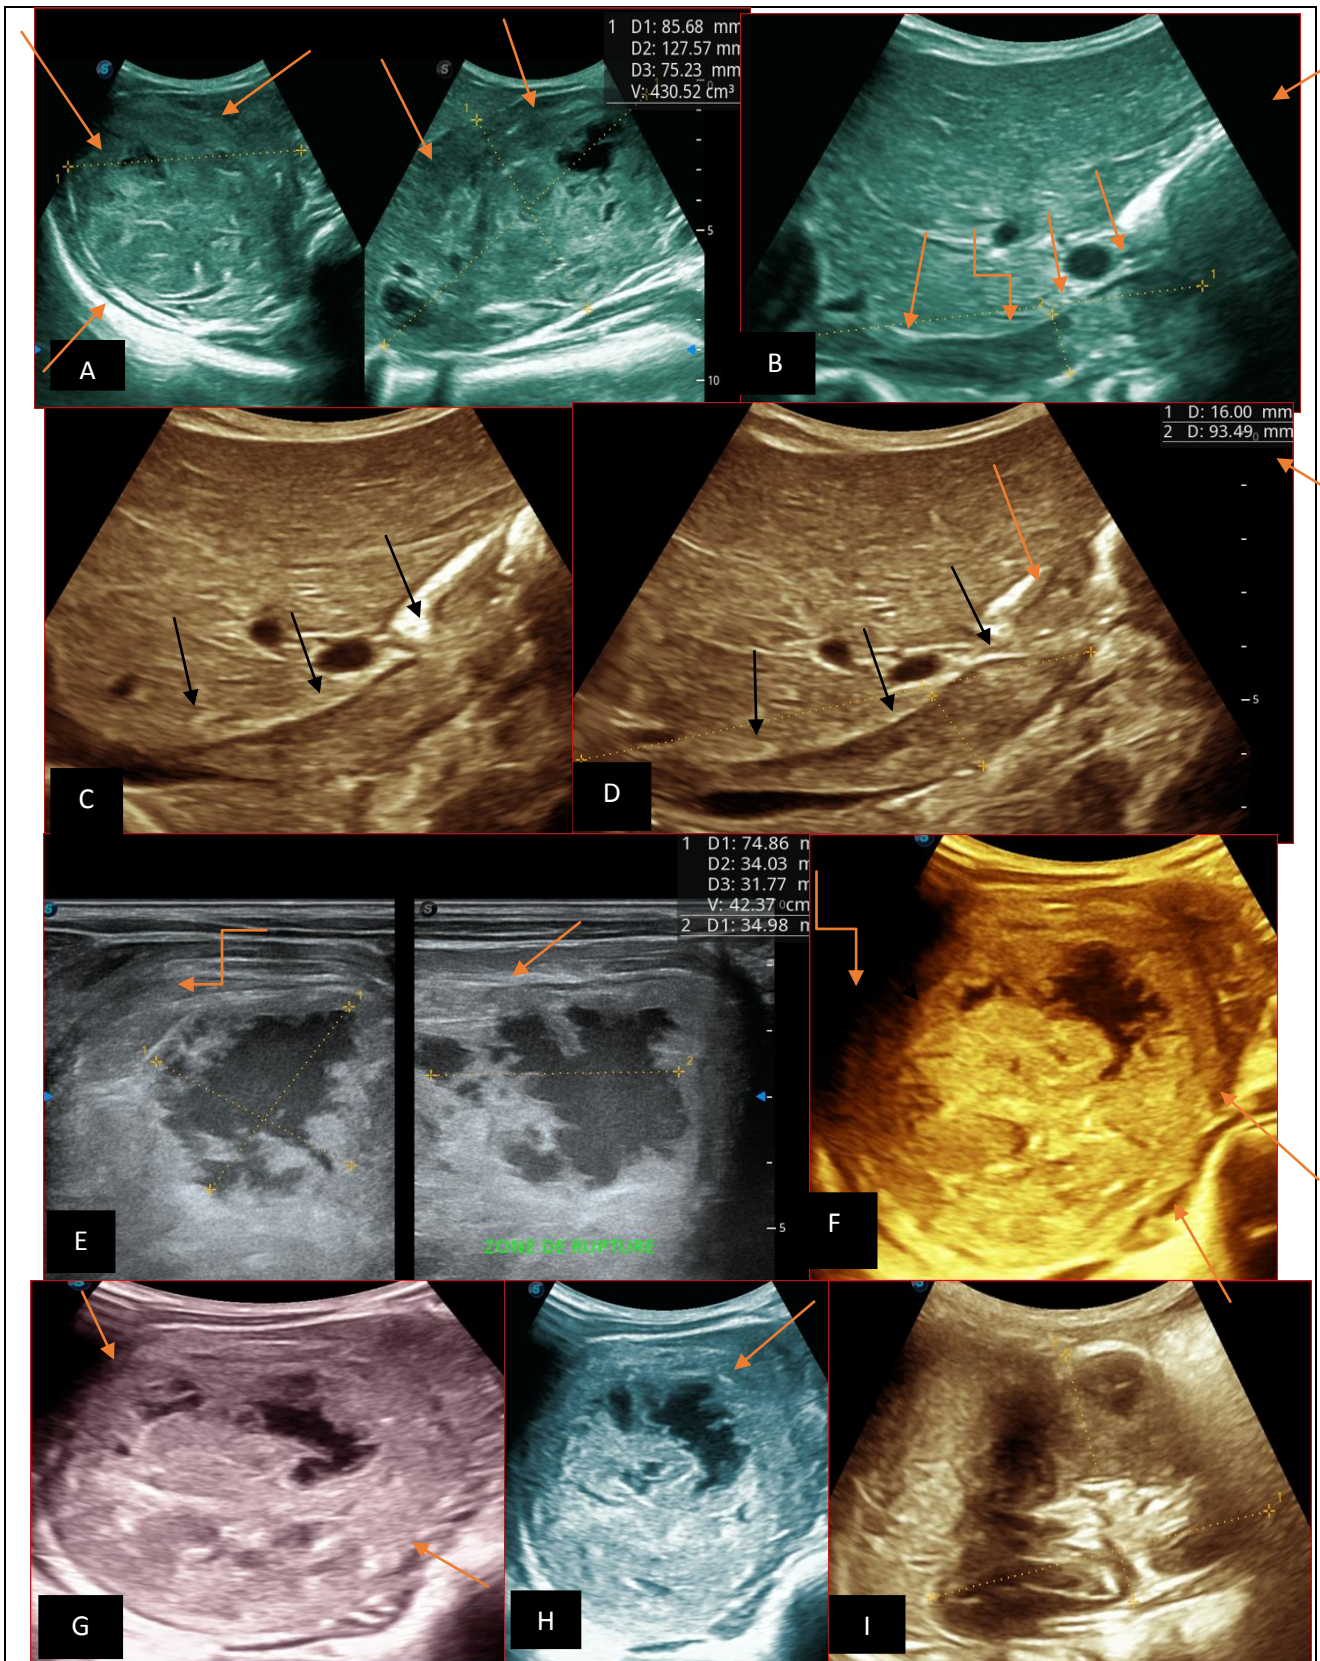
Abdominopelvic ultrasound check-up after 6 courses of chemotherapy in the same 5-year-old
